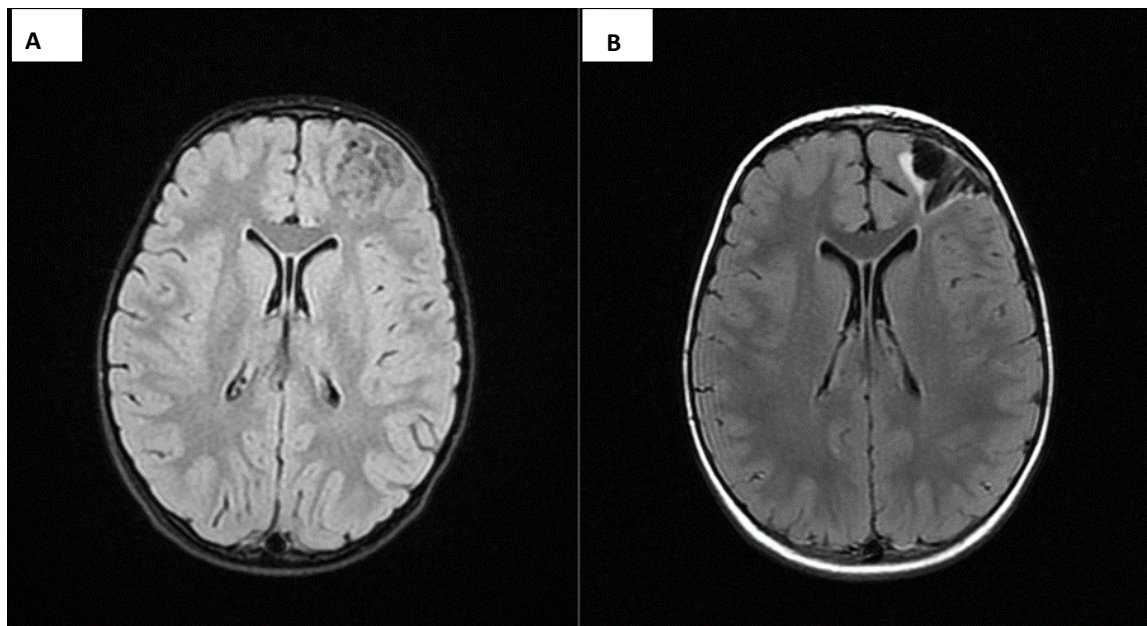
Representative MRI findings pre and post-operatively in our case of MA-M
